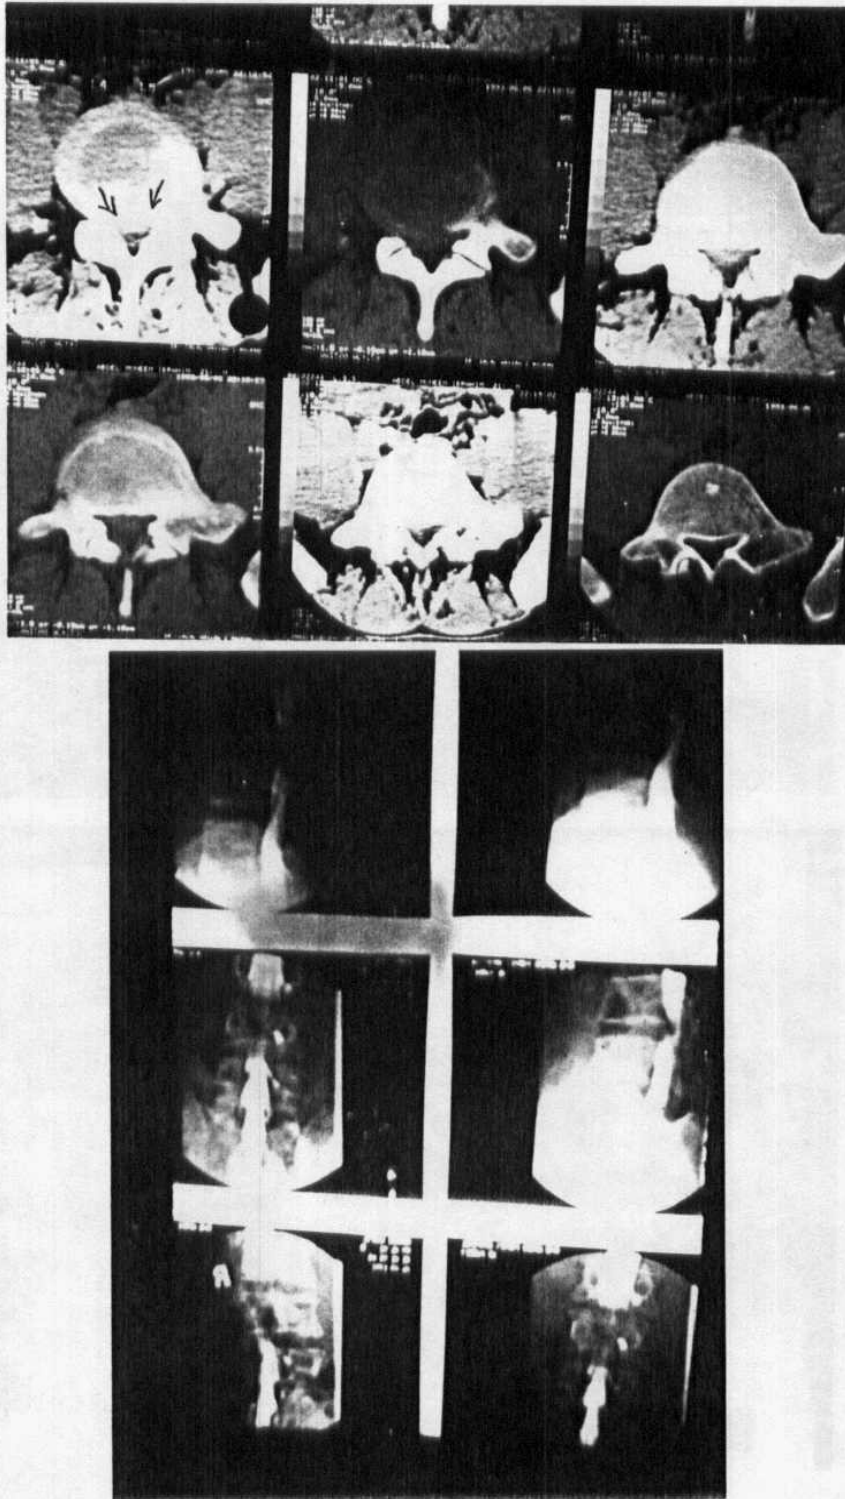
CT scan reported a big disc herniation at L45. But in Myelography and MRI the lesion was in L34. This was due to localization of the area examined by the scan, which can not detect the presence of sacralization.
